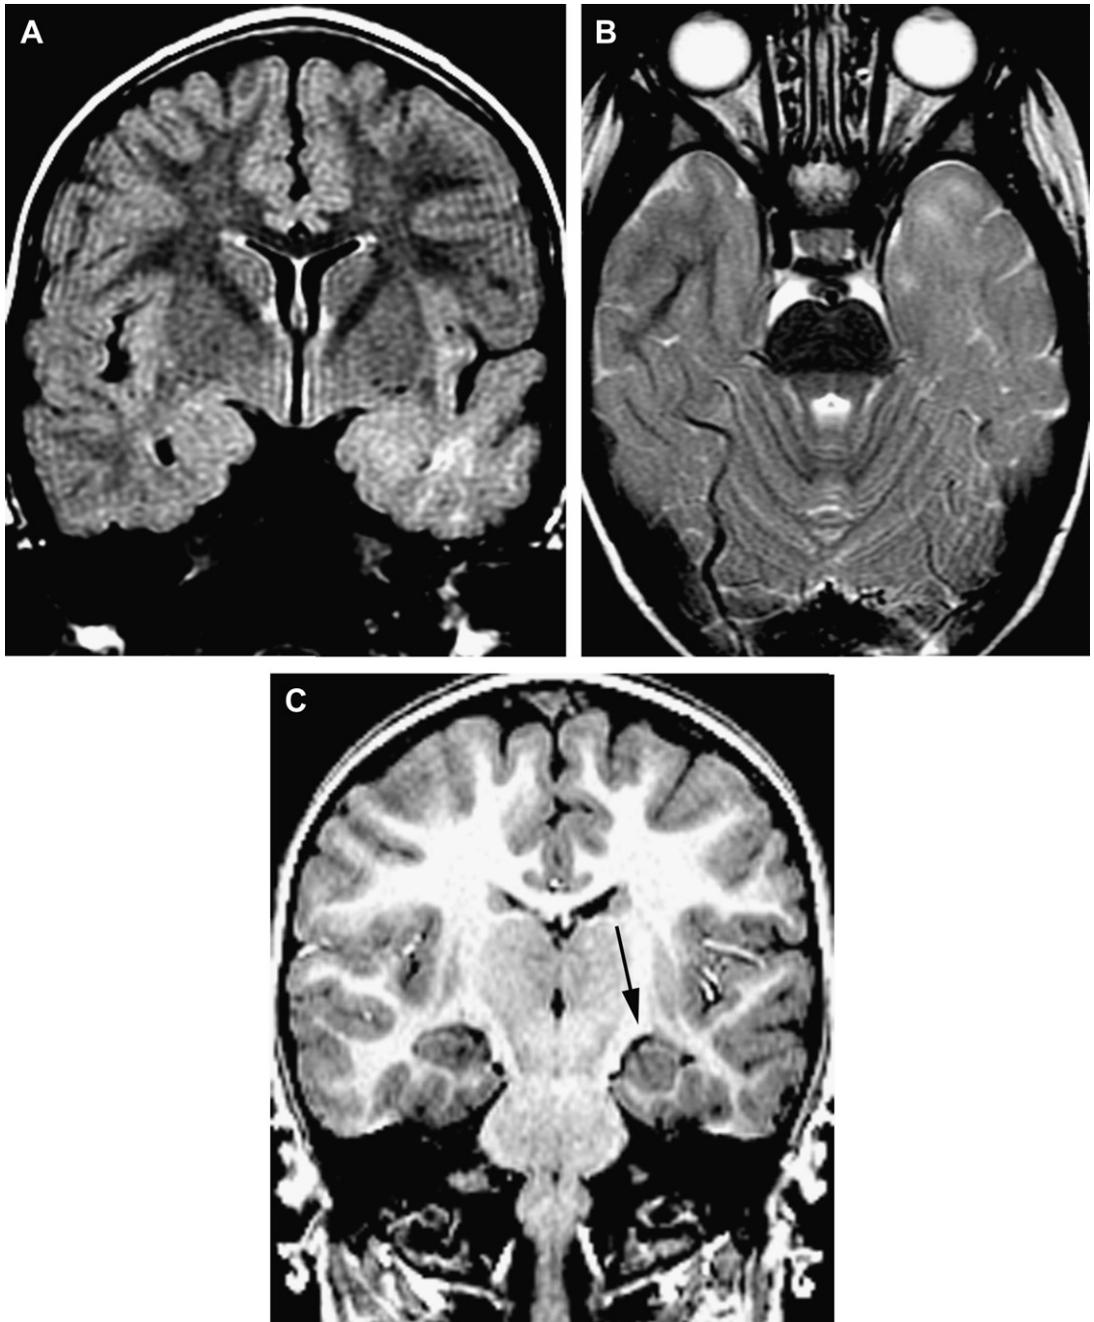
mMCD (formerly microdysgenesis) associated with hippocampal dysplasia. (A) Coronal FLAIR demonstrates diffuse bright signal of the anterior left temporal lobe with some loss of volume. (B) Axial T2 demonstrates the diffuse loss of contrast between the cortex and the white matter in the left temporal lobe. (C) Coronal high-definition T1 demonstrates a rounded, bulky, dysplastic hippocampus (*arrow*). After surgery, pathology disclosed mMCD of the temporal lobe and dysplasia of the hippocampus.
